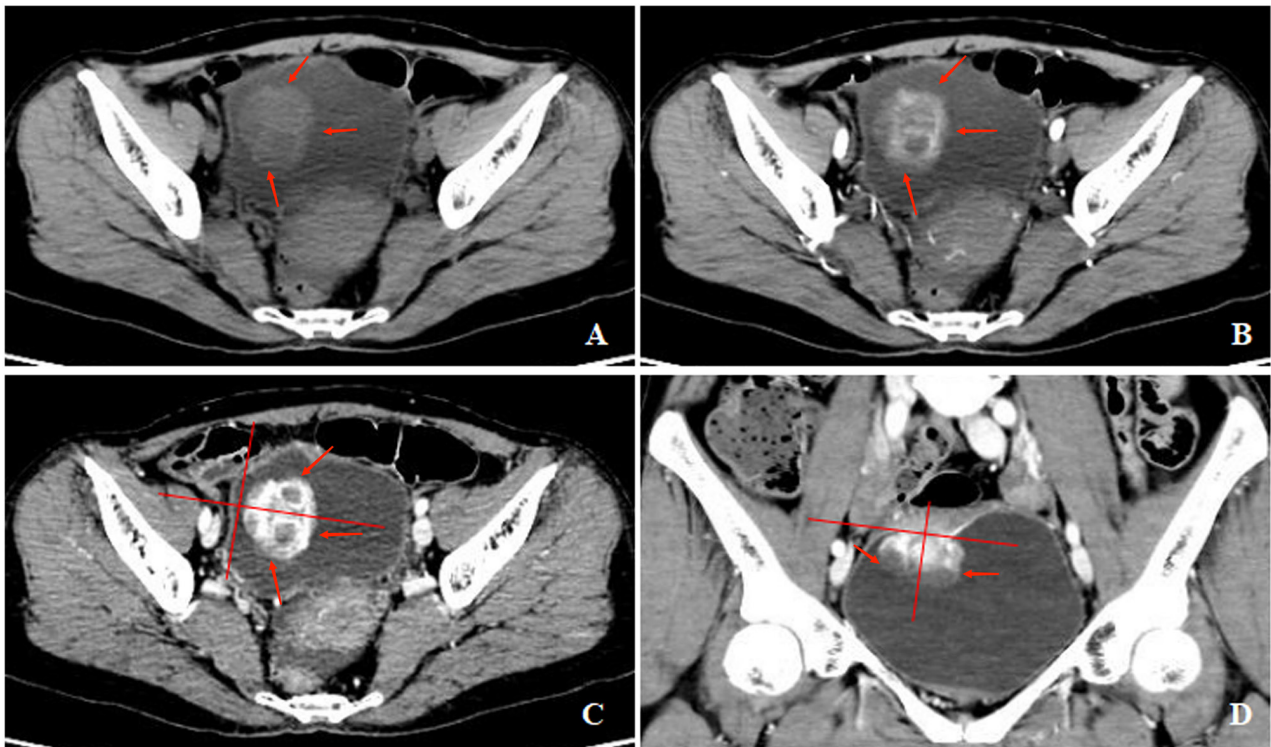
A 60-year-old woman with gross hematuria, painful urination, irregular blood clot. (A) Unenhanced CT scan of bladder showed a cauliflower-like soft-tissue mass with an endophytic growth pattern on the superior wall, with homogeneous density. (B-D) Contrast-enhanced CT scans revealed heterogeneous enhancement of the lesion and symmetrical change in the center of the lesion. CT, computed tomography.
